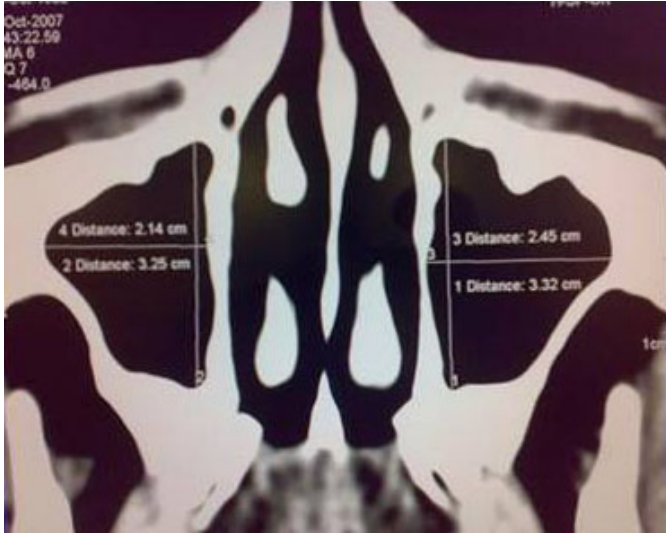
The width and length of the maxillary sinus measured from the reconstructed CT axial section.
